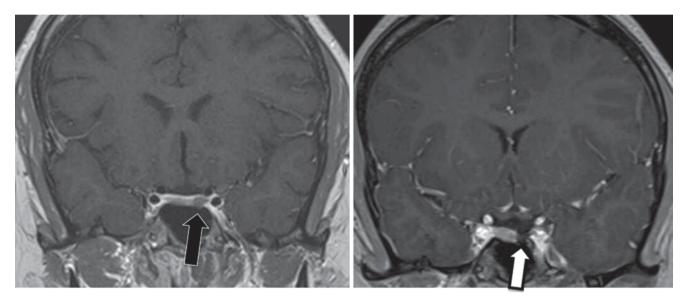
Pituitary microadenoma (ACTH-producing). a Preoperative coronal T1-weighted MRI with gadolinium reveals nonenhancing leftsided pituitary lesion (*black arrow*). b Postoperative image shows resection cavity (*white arrow*)
